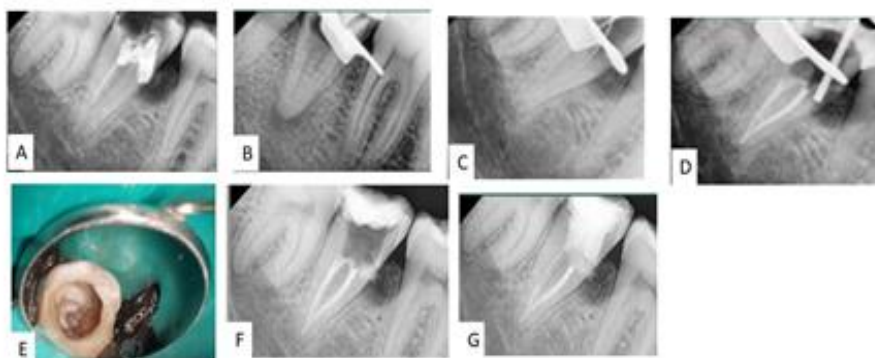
(a): Preoperative radiograph (b) Post GP removal (c) Working length determination (d) Obturation completed and placement of Abgel (e) Clinical photograph post MTA placement (f) Radiograph confirming correct placement of MTA in defect (G) Post operative radiograph with glass fiber post placed and core buildup completed
